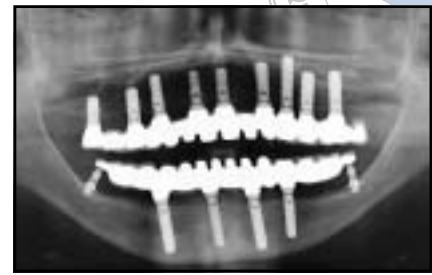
Panoramic radiograph showing a fixed full-arch prosthesis in the mandible supported by four anterior implants and two extraoral implants at the second molar sites, both 2.5 mm in length.
